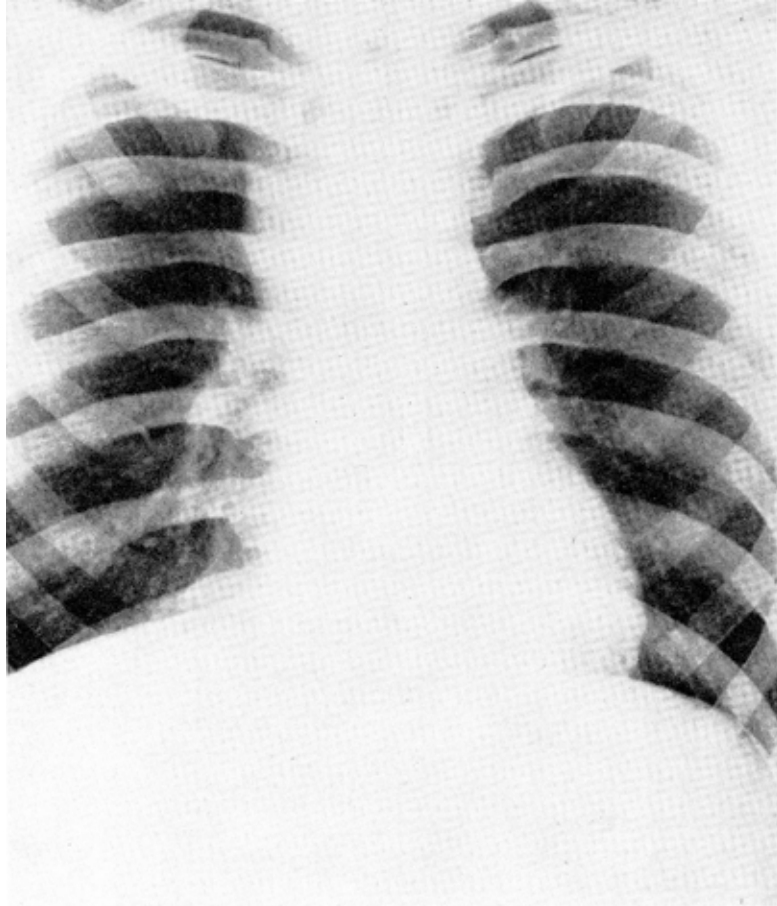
Roentgenogram showing sharply-defined mass in the upper mediastinum.
